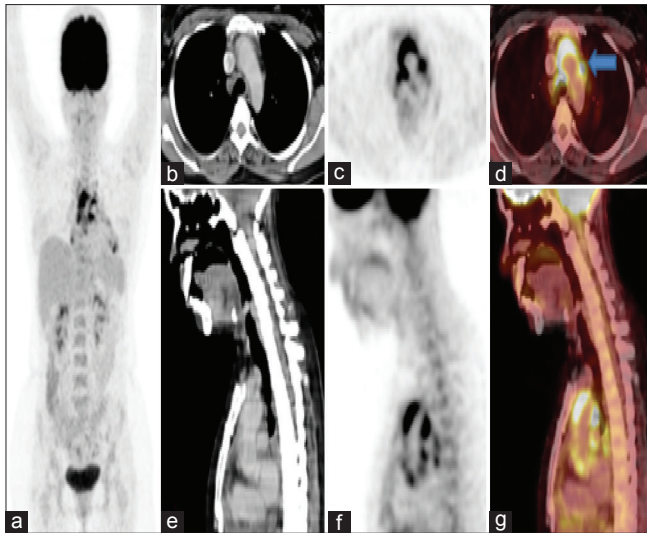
Case 3 (pretreatment): Maximum intensity projection image (a) showing increased fluorodeoxyglucose uptake in mediastinum. Axial (b-d) and sagittal (e-g) sections of contrast-enhanced computed tomography, positron emission tomography and fused positron emission tomography-computed tomography images showing increased fluorodeoxyglucose uptake in aortic wall with maximum standardized uptake value: 11.1, and arch of aorta maximum standardized uptake value: 9.5 (liver maximum standardized uptake value: 2.8)
